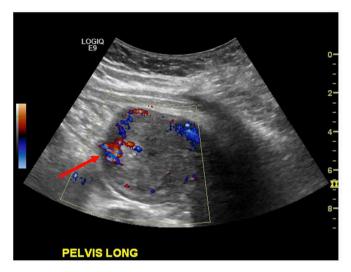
Transvaginal pelvic ultrasound showing 1.8×1.6×1.8 cm focal hyperechoic area within the endometrial region at the fundus of the uterus, with prominent vessels in the area.
